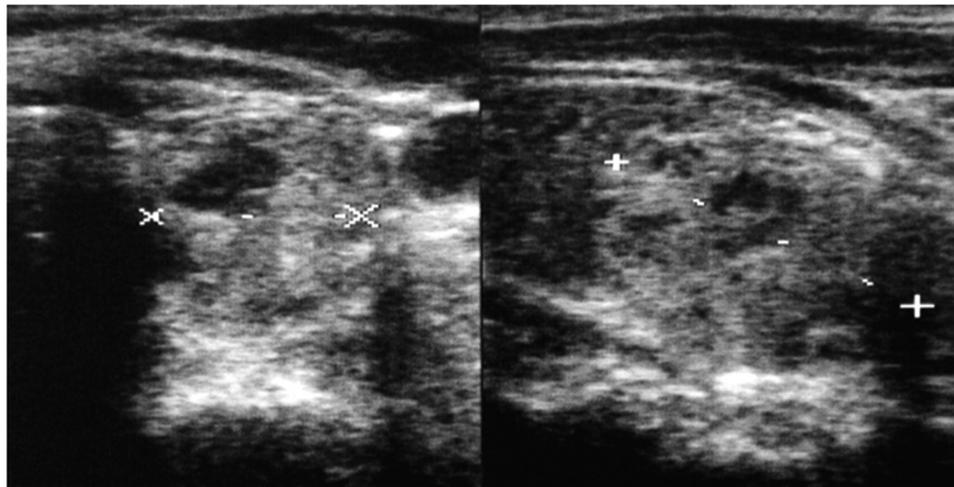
Initial ultrasound (crosses show the left-sided thyroid nodule).
